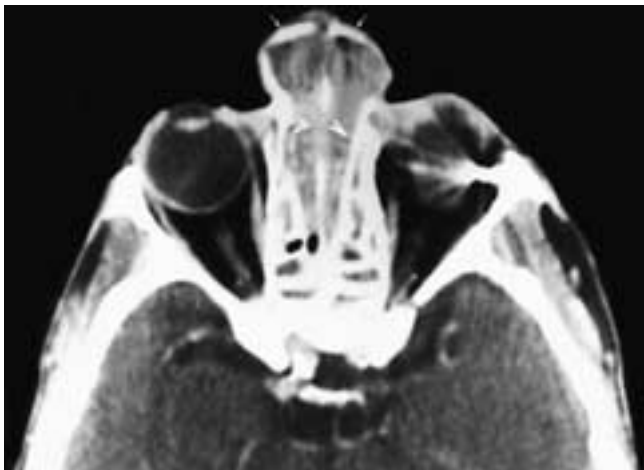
Axial contrast-enhanced CT scan shows bilateral nasal masses that have displaced the nasal bones anterolaterally (*small arrows*) and thinned part of the nasal septum. The upper nasal fossae are widened by the nasal masses, and the medial aspect of the each ethmoid complex has been displaced laterally (*arrowheads*). There are also secretions in both ethmoid sinuses. This patient had nasal polyposis and sinusitis.
